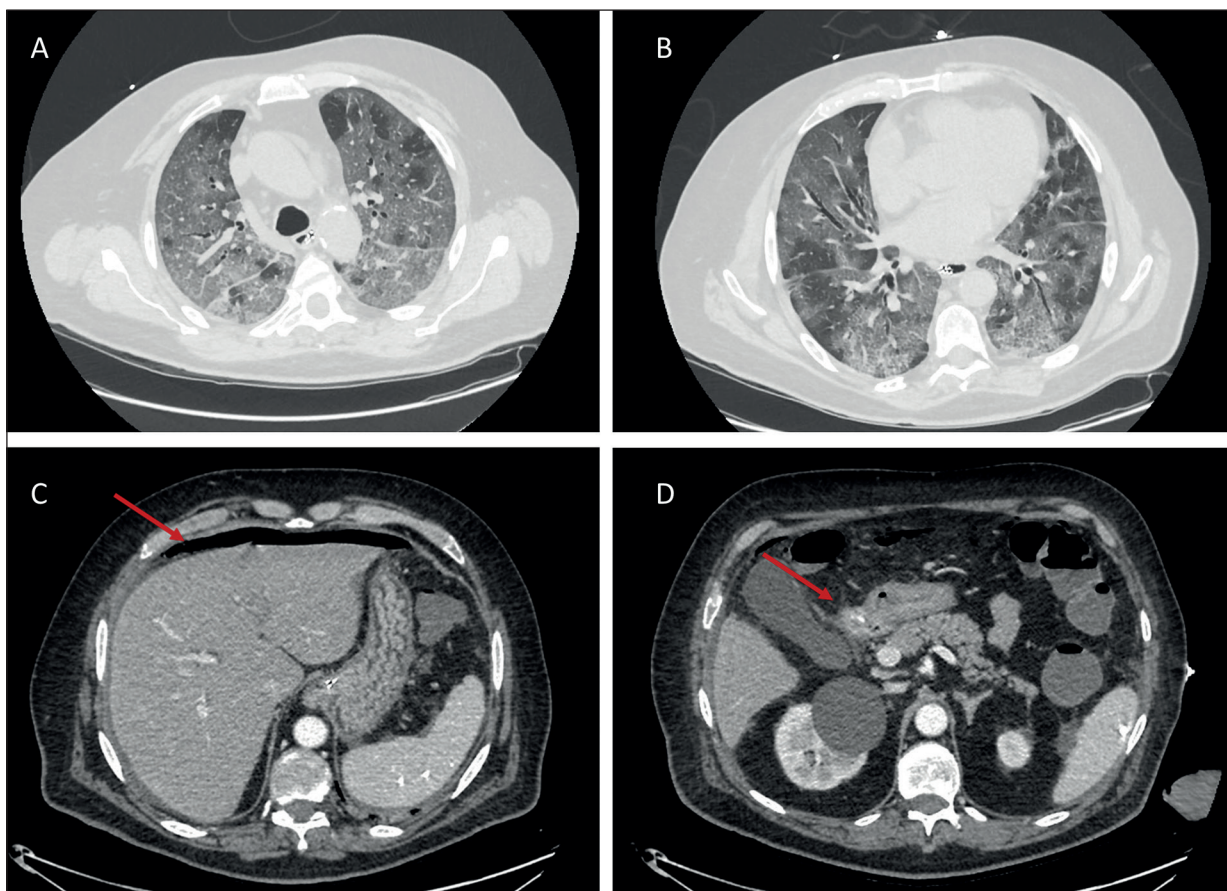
A-B, Chest CT at admission showing severe interstitial SARS-CoV-2 pneumonia in all segments. C-D, Abdominal CT during admission showing the presence of a pneumoperitoneum (Panel C, red arrow) and active arterial blush in the duodenal bulb (Panel D, red arrow).
